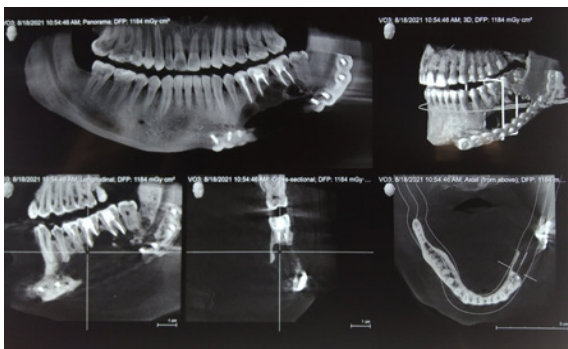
CBCT showed an expansive lesion with 4.62 cm × 2.8 cm × 2.2 cm in extension with perforation of buccal and lingual cortical plates extending from apical region with respect to 33 to 38.
